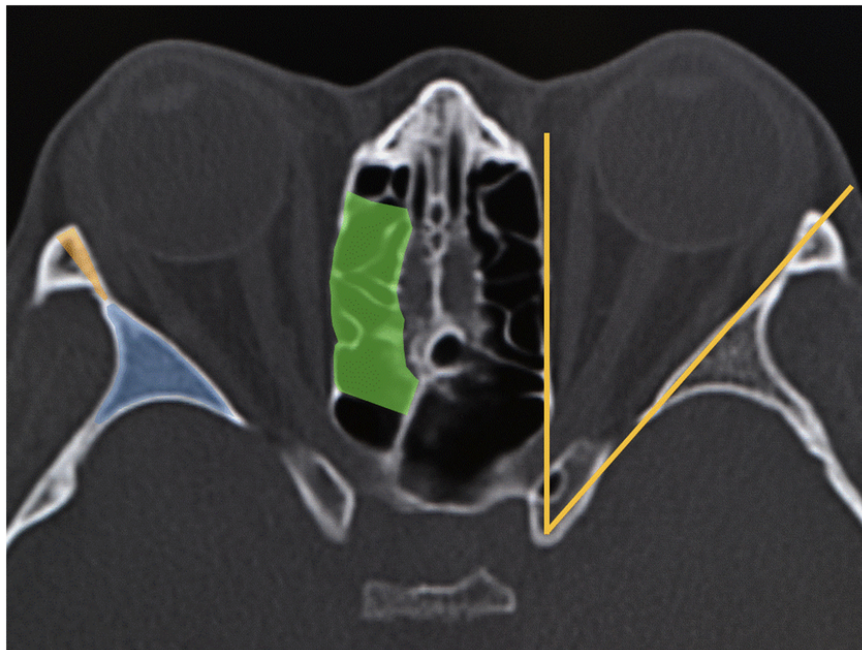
Axial computed tomographic image of the orbit. The lateral walls are oriented to an angle of 45° lateral to the sagittal plane, whereas the medial walls of each orbit are oriented in the sagittal plane (the yellow solid lines)⁴
